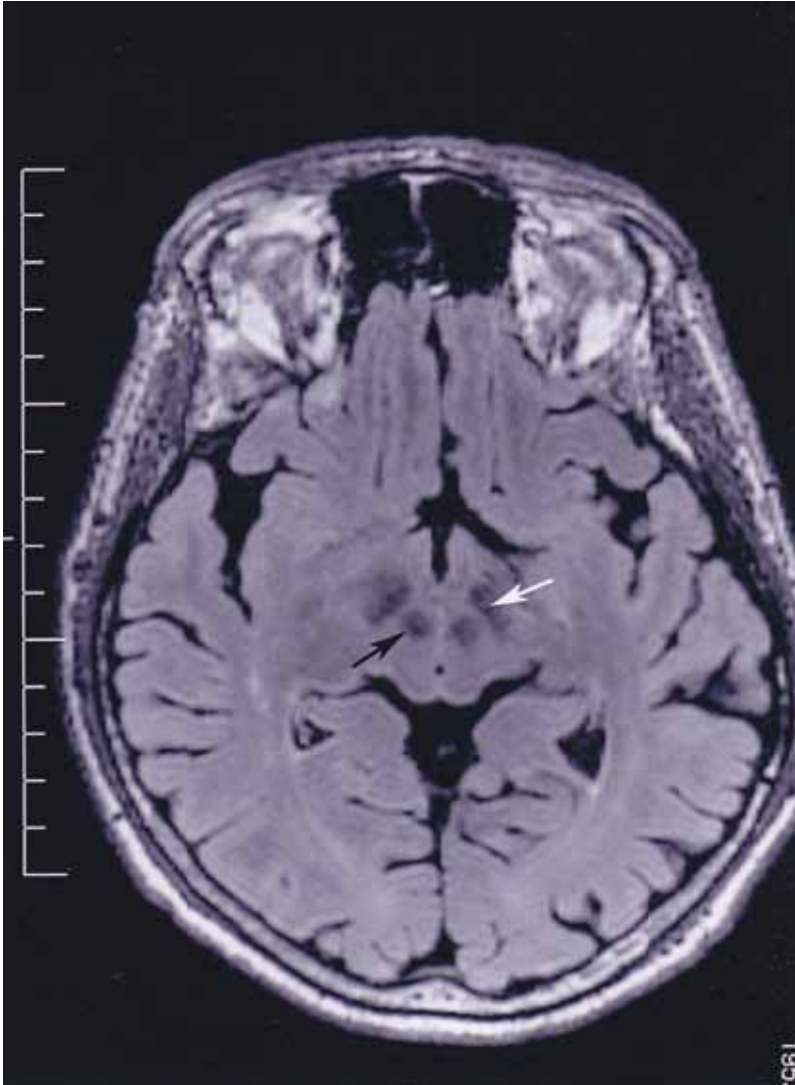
Subthalamic nucleus (white arrow) and nucleus ruber (black arrow) as seen on FLAIR sagittal T2 cube sequences obtained on a 3T MR scanner.
